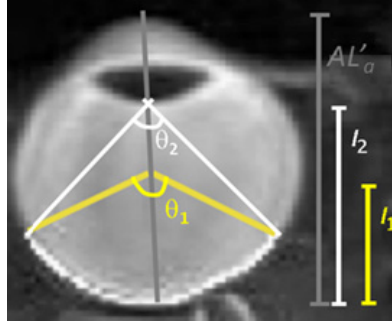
Angles and distances used to define similar retinal regions for comparison between PCI and MRI. θ_1 and θ_2 are the angles subtended approximately at the center of the eye (MRI) and at the posterior lens vertex (PCI), l_1 and l_2 are the corresponding distances, and AL'_a is the axial length of the eye obtained from the Lenstar.
